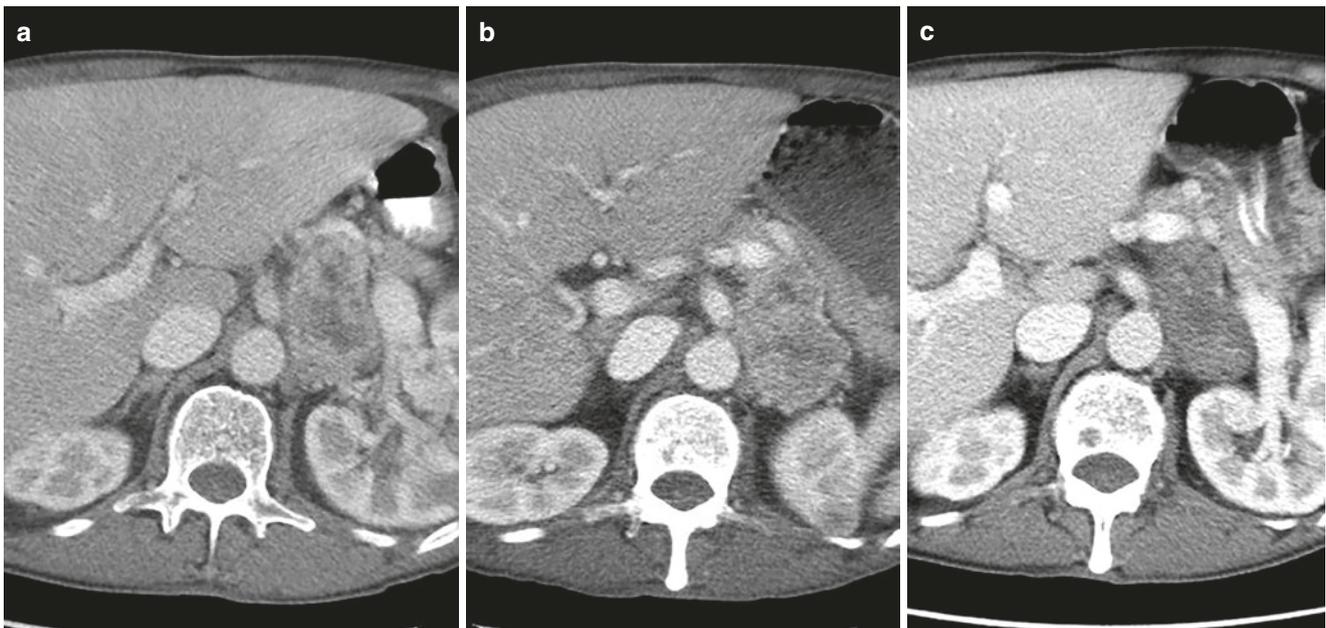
Adrenal metastasis treated with immunotherapy. (a) Initial contrast-enhanced CT image demonstrates a large left adrenal mass. (b) The mass remains heterogeneous and is larger on a follow-up CT
